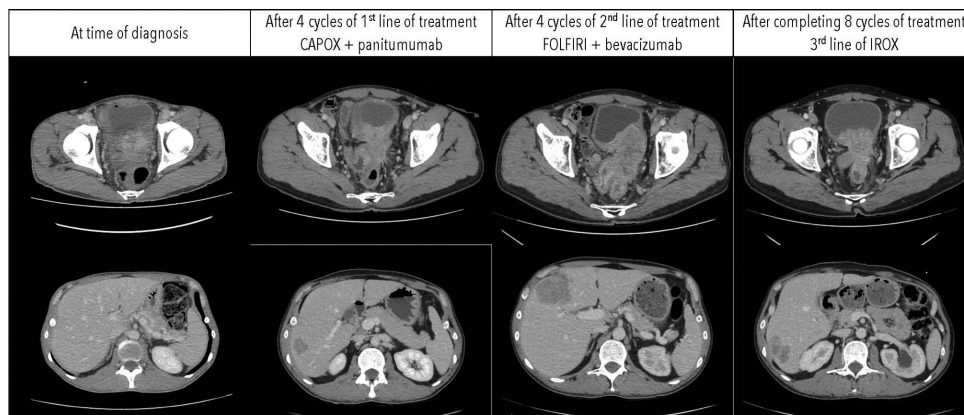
The patient's CT scans at different stages of treatment. The first CT was obtained at the time of diagnosis. The subsequent CTs were obtained after the first line of treatment (CAPOX with panitumumab), the second line of treatment (FOLFIRI with bevacizumab), and the third line of treatment (IROX) were completed.
